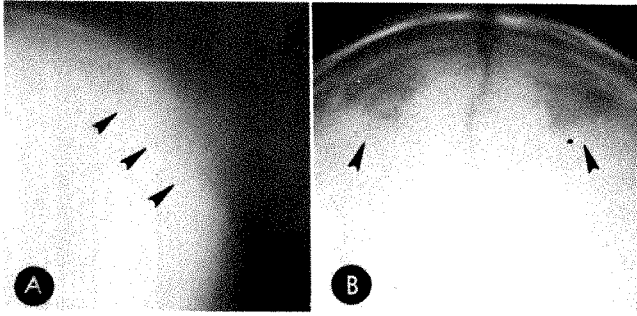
A, Lateral skull roentgenogram of 4-week-old infant with large posterior fontanelle and bulging of local soft tissues (arrows). B, Frontal view of same patient 4½ years later showing large parietal foramina (arrows).
